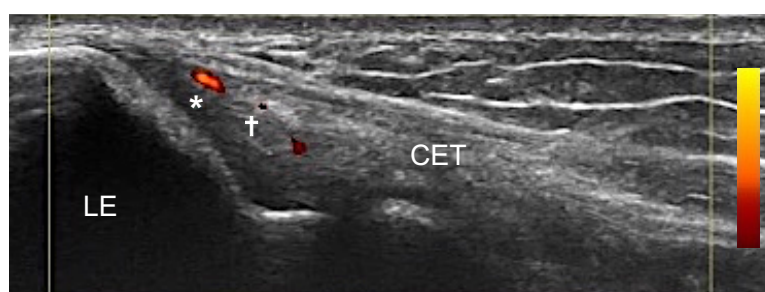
Enthesal thickening (†, grade 2), hypoechogenicity (☆, grade 1) and power Doppler signal (red) in the left common extensor tendon enthesis of an asymptomatic patient with moderate-to-severe psoriasis. CET: Common extensor tendon; LE: Lateral epicondyle.
